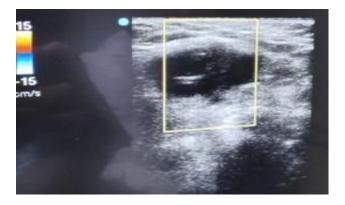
Ultrasonography revealed a hypoechoic left inguinal mass, with ill-defined margins.
